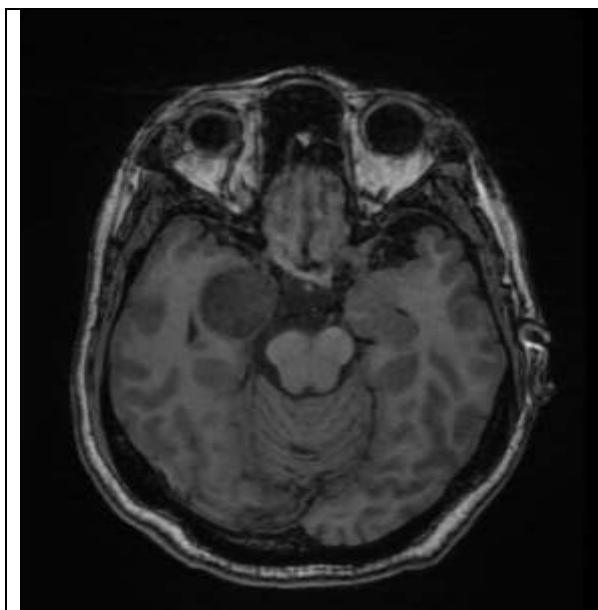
MRI brain showing 3.5X2.8cm large enhancing cavernous sinus lesion extending to superior orbital fissure and encasing optic nerve
